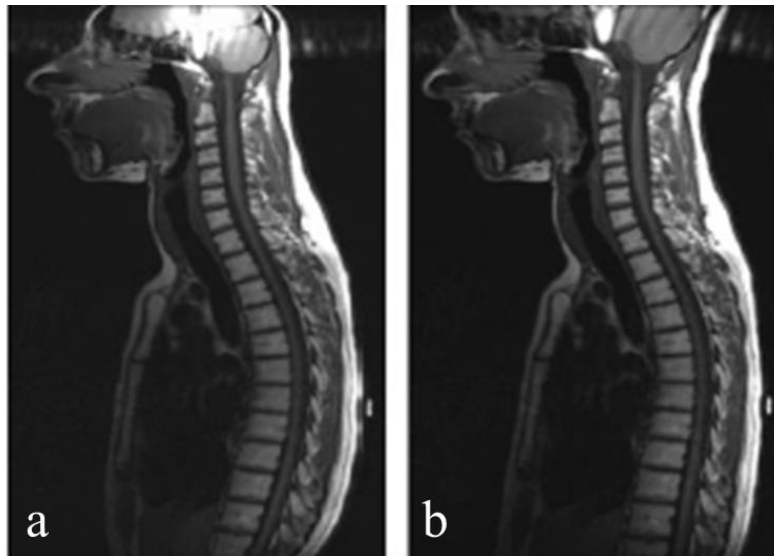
Gradient field non-linearity artifact. a) MR image obtained with SE sequence and large field of view, b) Image obtained with a vendor-supplied correction algorithm shows correction of the geometric distortion (from Mahesh, 2004).
